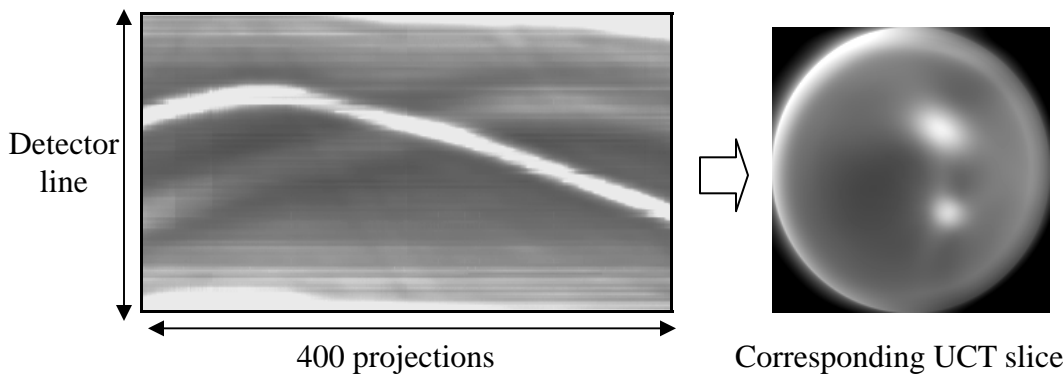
Example of a sinogram which associates with the reconstruction of the corresponding ultrasound CT slice. 400 projections were taken from 180 degree with each increment of 0.45 degree.
